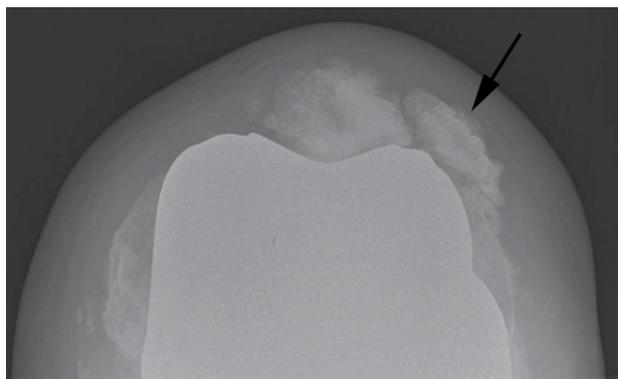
Patellar Necrosis. A 68-year-old man, seven years after total knee replacement. Axial radiograph of the knee prosthesis shows bony sclerosis with fragmentation of the patella (arrow).
